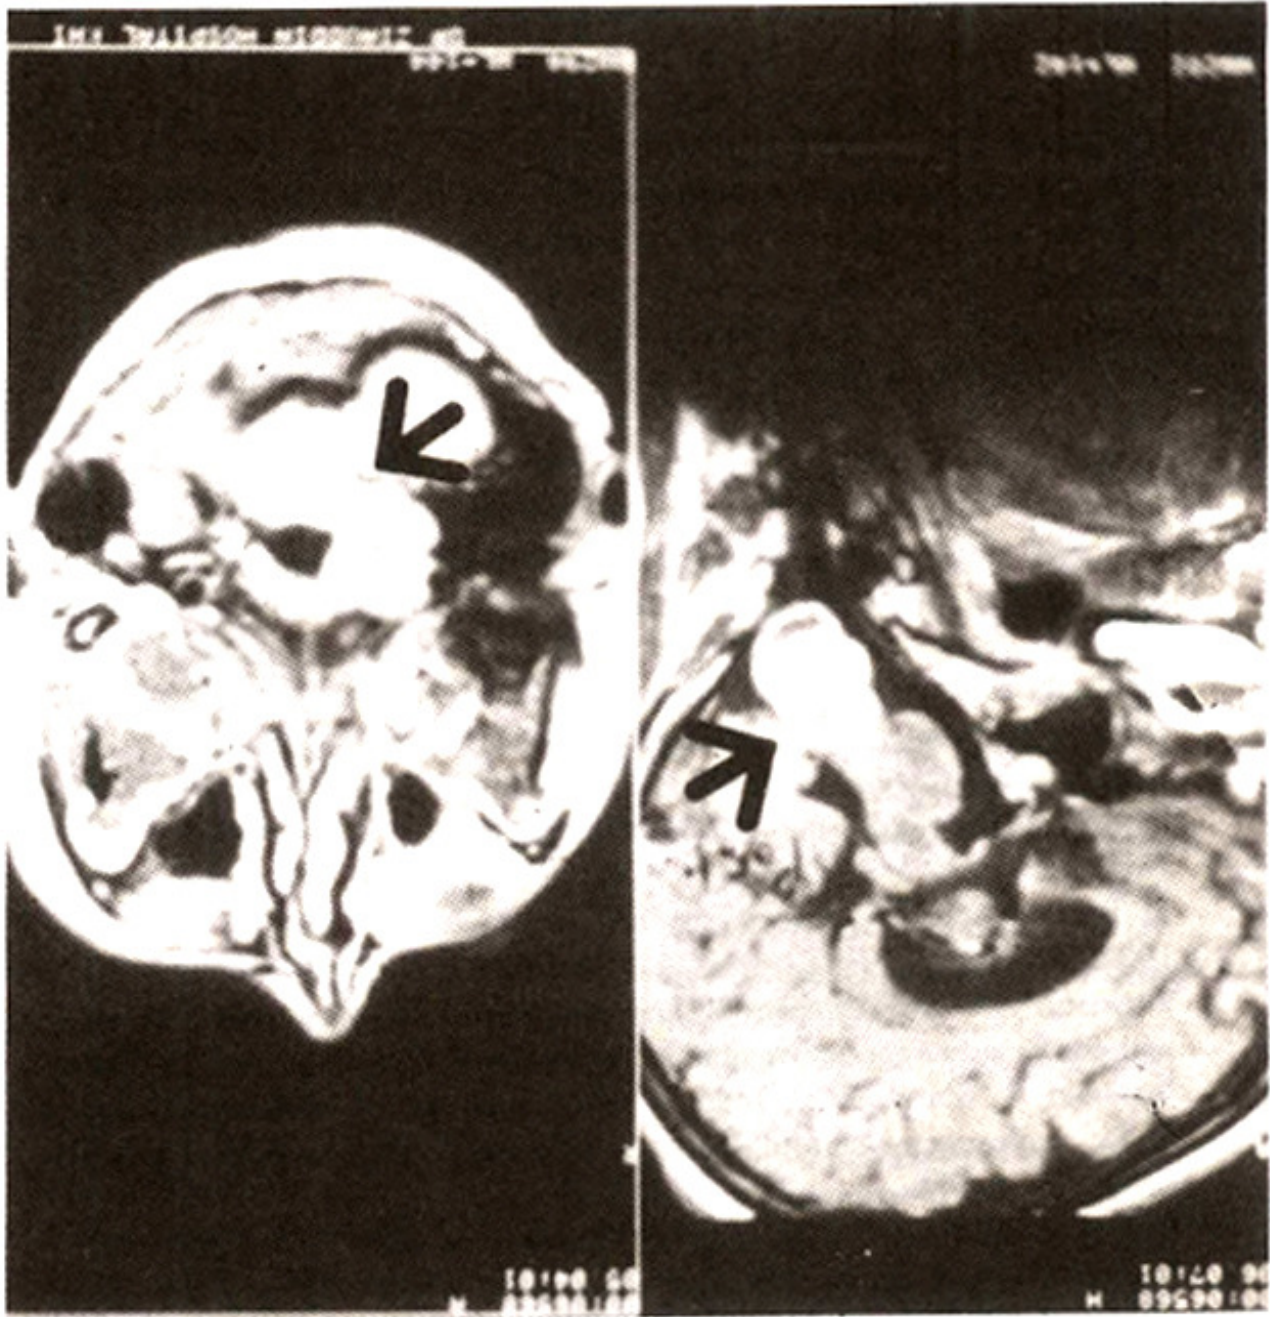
A post-contrast coronal and axial MRI showing a dumb-bell neurinoma in the right jugular foramen.
